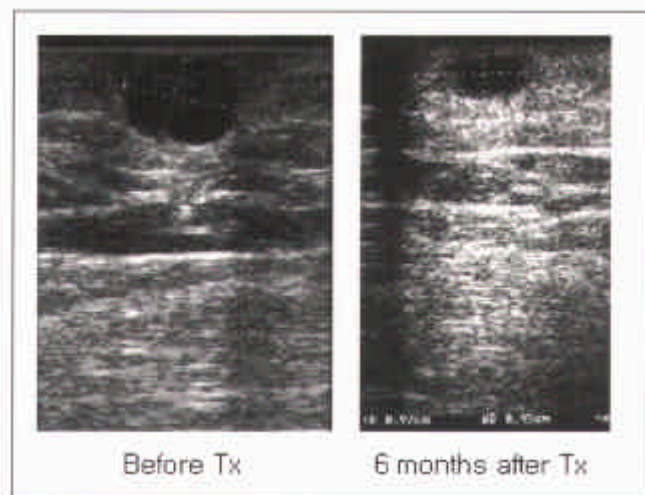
Ultrasonography in a 64 year-old female before and after Ho treatment of melanoma . Decreased tumor size is noted until 6 months after treatment.
